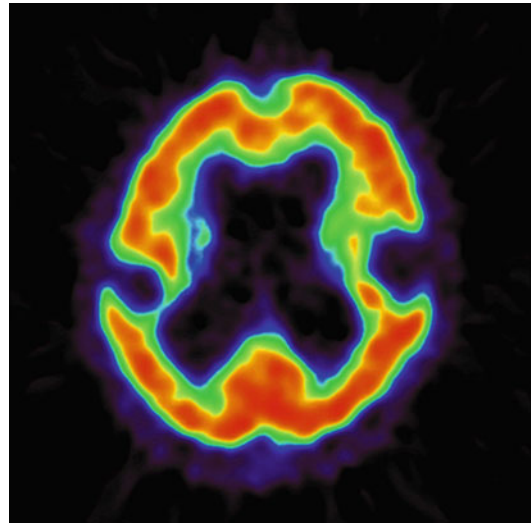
^{18}F -FDG PET images of normal pressure hydrocephalus
